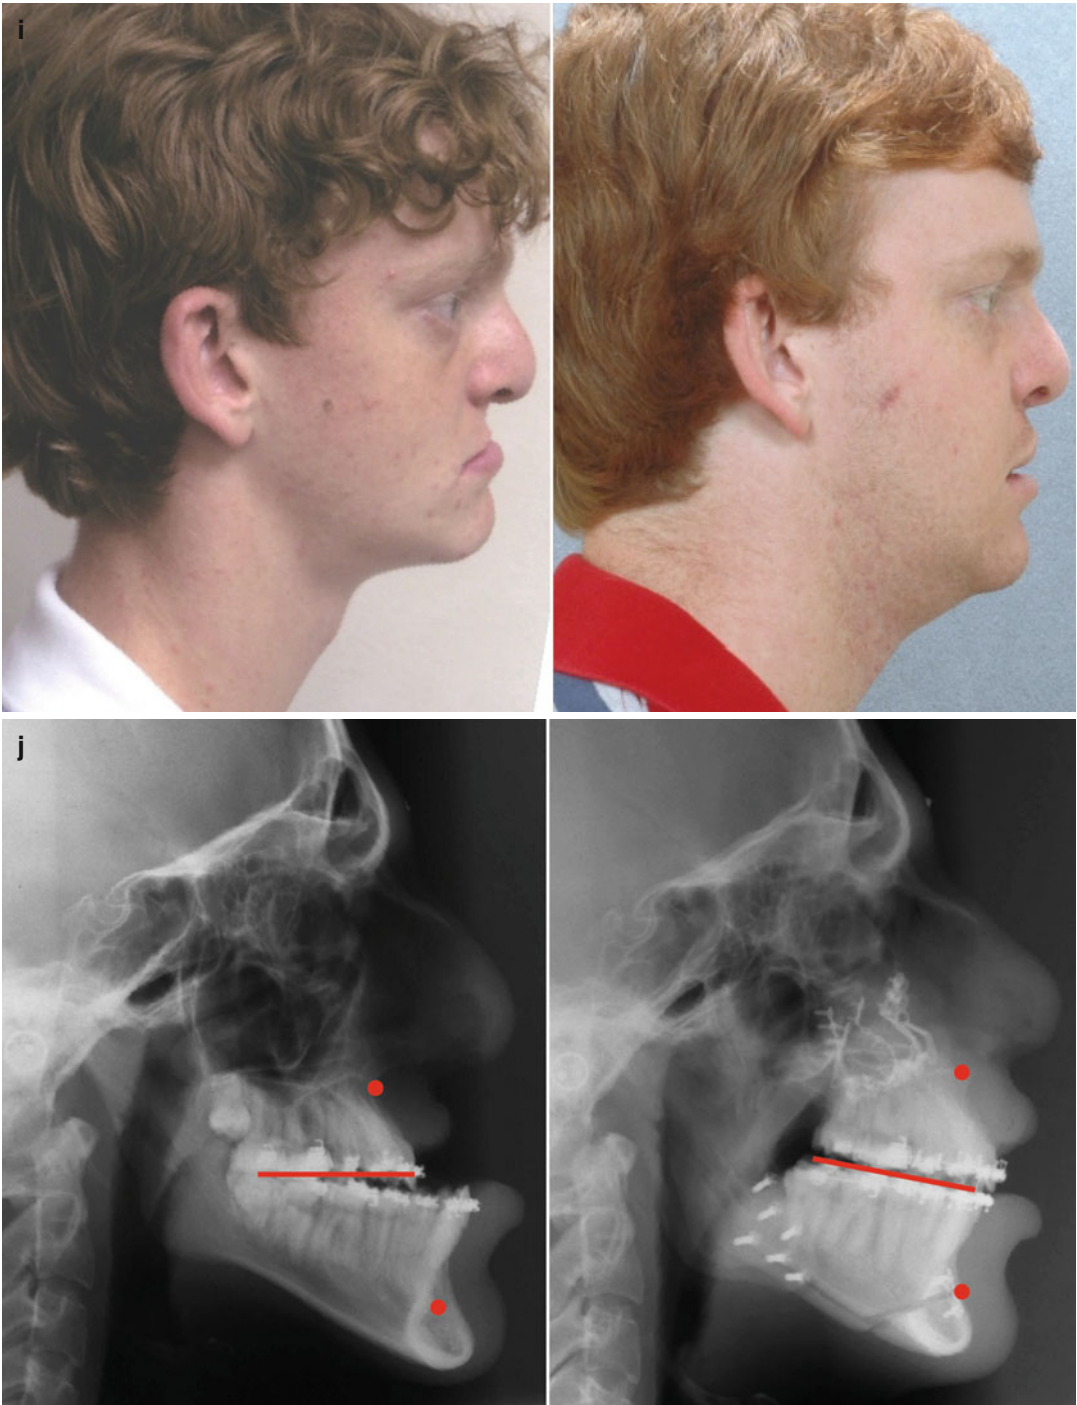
(continued) (i) Profile views before and after reconstruction/rehabilitation. (j) Lateral cephalometric radiographs before and after surgery
